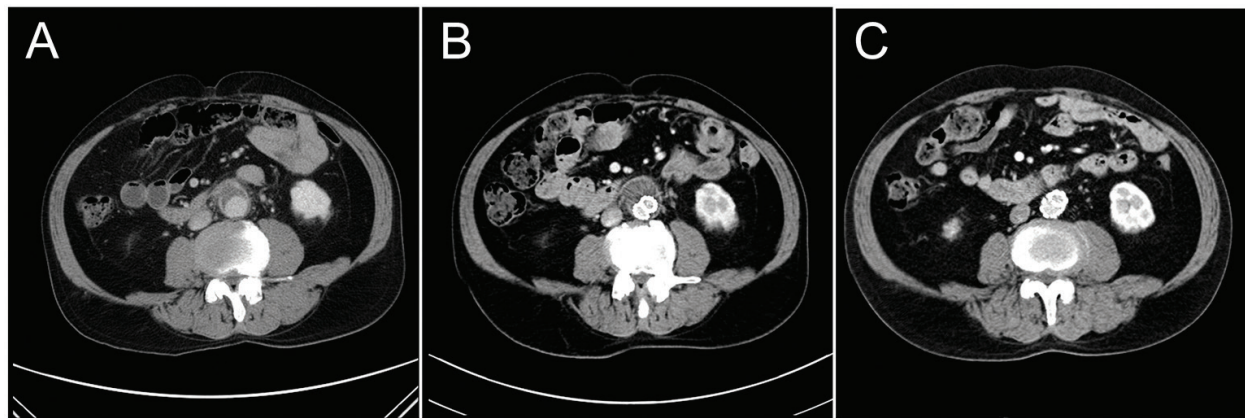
(A) Infected infra-renal abdominal aortic aneurysm in a 68-year-old diabetic male patient (B) CT angiography 2 weeks after EVAR showed residual aneurysm but resolved periaortic inflammation. Percutaneous drainage of the aneurysm was done. (C) With long-term oral antibiotic suppression, the aneurysm disappeared completely on CT angiography 2 years later.
